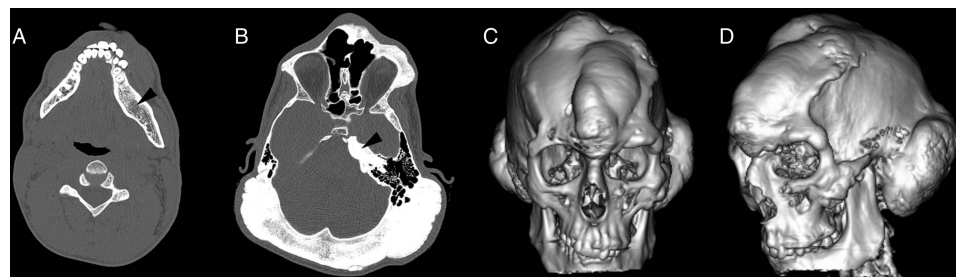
Axial CT images demonstrating osseous expansion with medullary ground glass change in the body of the left mandible (arrow—A). Radiological differential diagnosis includes polyostotic fibrous dysplasia. Hyperostosis is seen to affect the entire occipital bone, the left petrous apex (arrow—B) and the left infraorbital margin. Reconstructed images (C and D) revealing asymmetrical osseous overgrowth resulting in characteristic craniofacial abnormalities.
